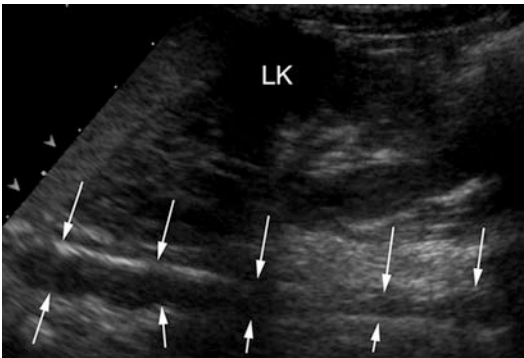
Narrowed aorta in mid-aortic syndrome clearly shown on ultrasound
